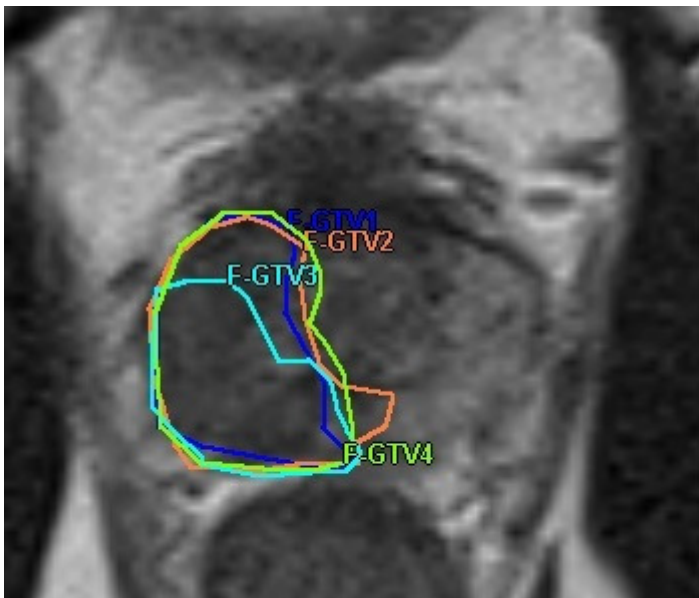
Example of four separate delineation attempts for one F-GTV (for each F-GTV, contours are combined from all mp-MRI data)
